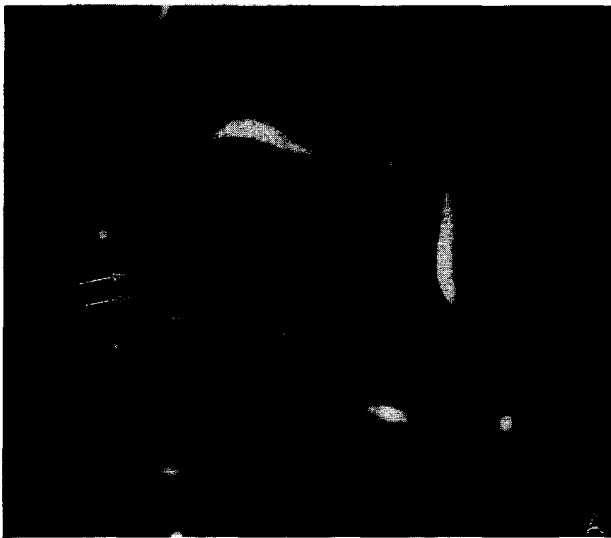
Tibiocalcaneal ligament: (A) Fat saturated T2WI oblique coronal image shows thick tibiocalcaneal ligament.(arrows) (B) Ultrasonography also demonstrate the tibiocalcaneal ligament clearly.(arrows)
